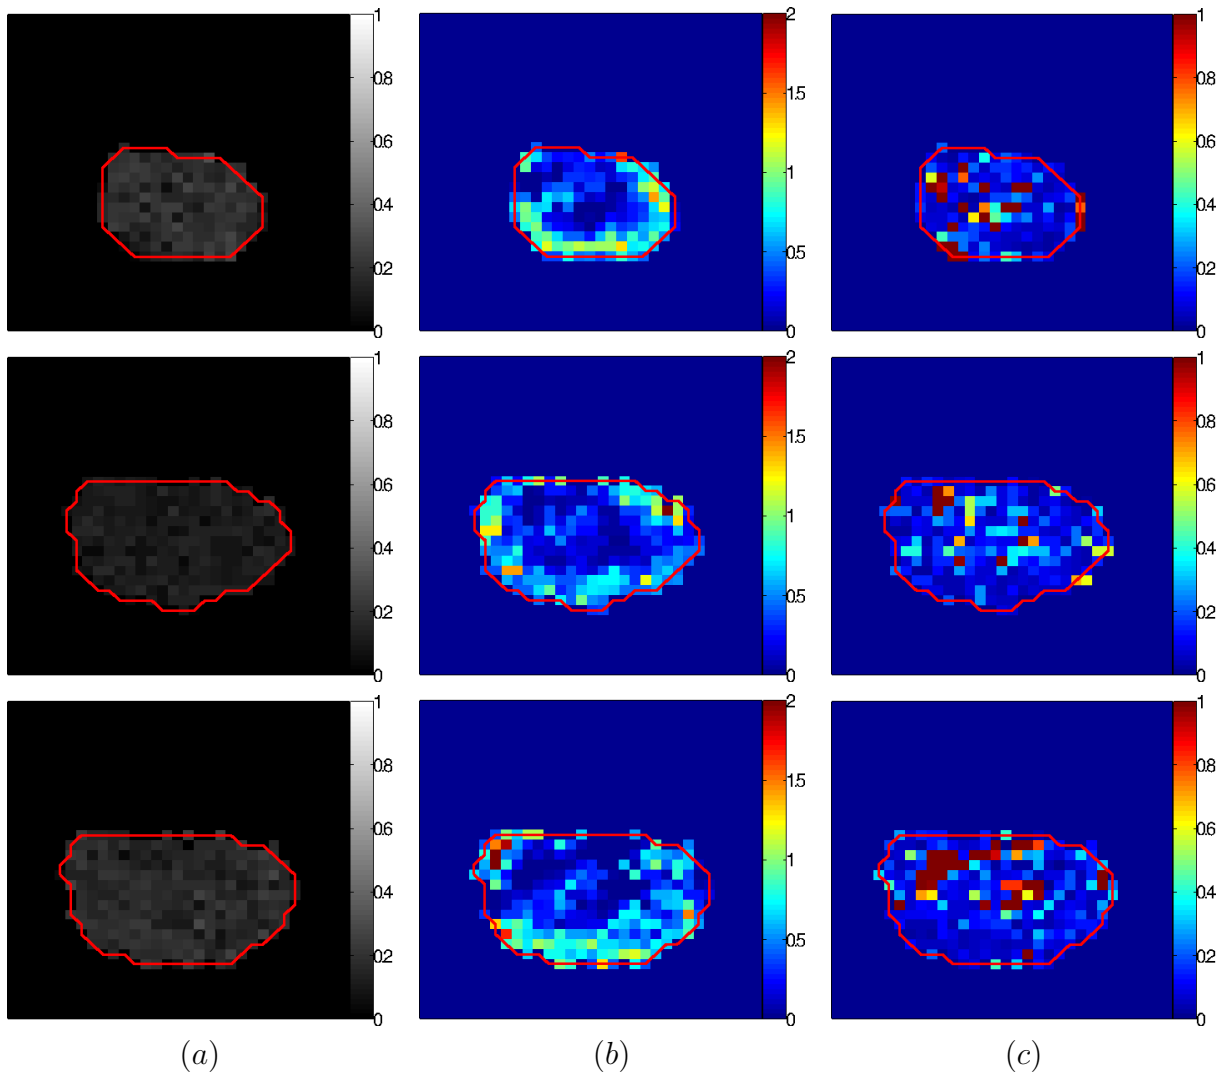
Pharmacokinetic parameter maps together with corresponding DCE-MRI baseline images: (a) DCE-MRI (b) k_{ep} (c) v_e . Each row corresponds to a longitudinal time point: Row 1 (day 21), Row 2 (day 23), Row 3 (day 24)
